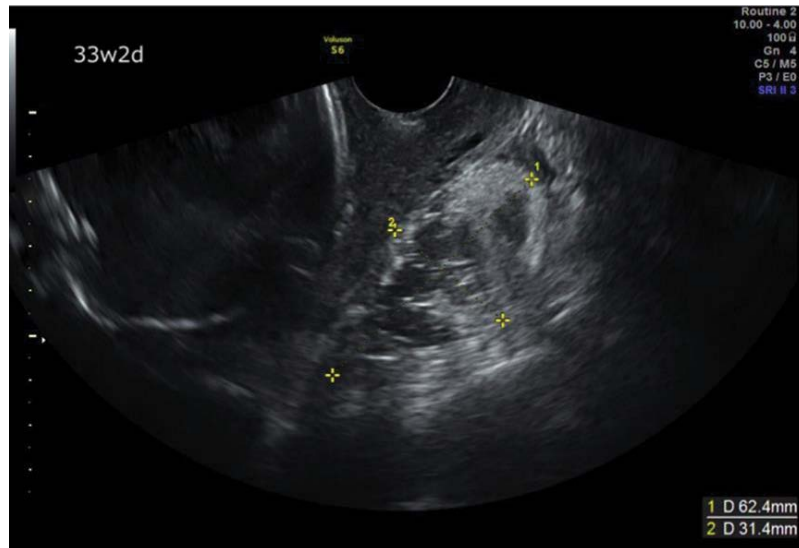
Transvaginal sonography at 33 weeks and 2 days of gestation showing a 62 × 31.4 mm ovarian mass in the Douglas pouch.
